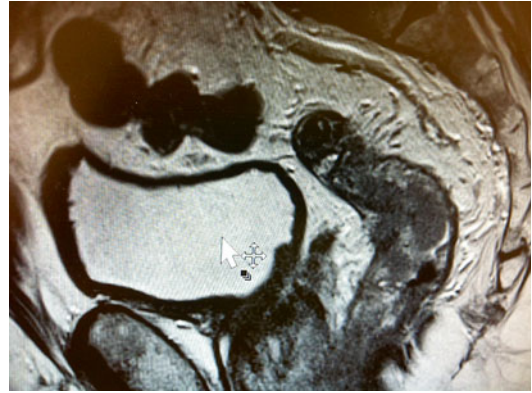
This MR image shows a T3N1V1 mid rectal tumour with a potentially involved circumferential margin. There is a plaque of high signal intensity in the presacral space. The patient subsequently underwent long course chemoradiotherapy
